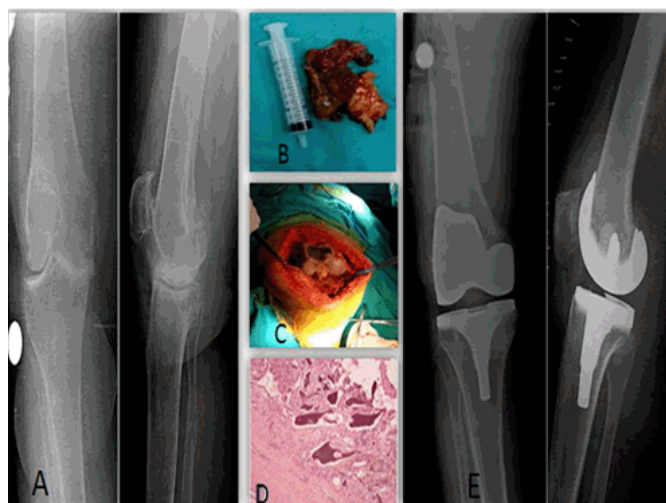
(A) Preoperative anteroposterior and lateral radiographs, (B) Black discoloration of the synovial tissue, capsules, (C) Black discoloration of surface of the tibiofemoral joint and the femur, (D) Mononuclear cell infiltration in focal focus is observed around the synovial cartilage fragments, and (E) Postoperative anteroposterior and lateral radiographs of the patient.
